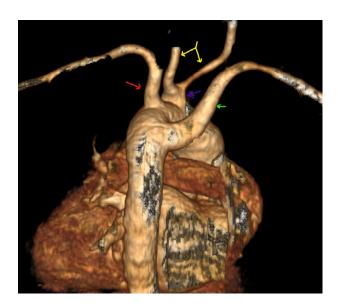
Posterior view of a CT angiogram with 3D reconstruction showing a common origin (blue arrow) of bilateral carotid arteries (yellow arrow) arising from the aortic arch who is called a truncus bicaroticus associated with arteria lusoria (green arrow) / left subclavian artery (red arrow).
